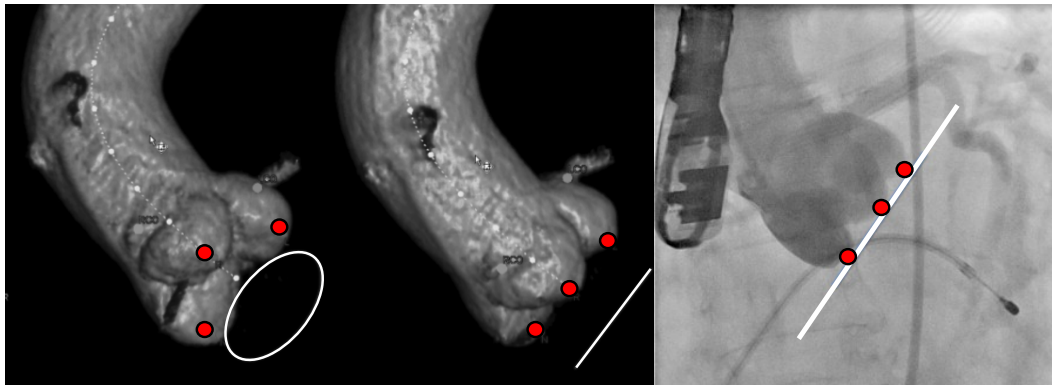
Left: CT volume renderings of an aorta with different virtual XRF projection views. The view in the middle aligns the inferior portions of all 3 coronary cusps, indicating that the annulus is parallel to the source-detector axis, as opposed to the view on the left (image modified from [18]). Right: An example XRF image during an aortogram, where all three cusps are aligned and therefore at the optimal XRF projection angle (image modified from [19]).
